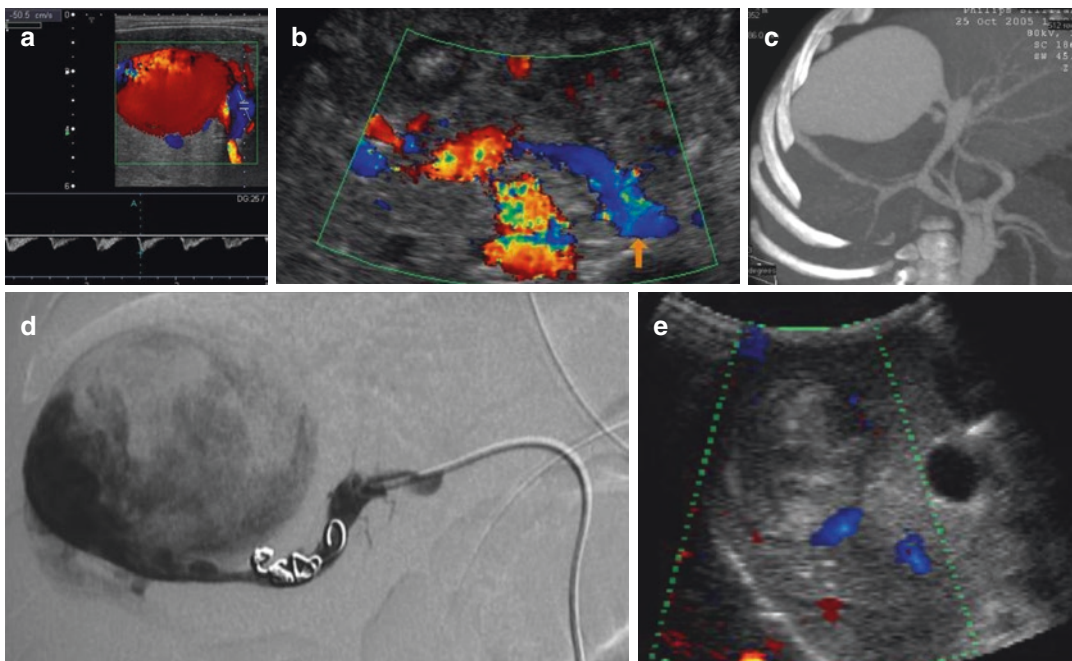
Congenital arterio-portal fistula. Three-month-old boy presenting with recent difficulties for feeding, diarrhea, and blood in the stools. (a) US Doppler shows a large ectatic vascular lesion with reversed-flow and arterialization of the portal flow highly suggestive of an arterio-portal shunt. (b) Color-Doppler shows the reverse flow in the splenic vein in relation with severe portal hypertension secondary to the arterio-portal fistula. (c) CE-CT confirms the direct communication of the ectatic
